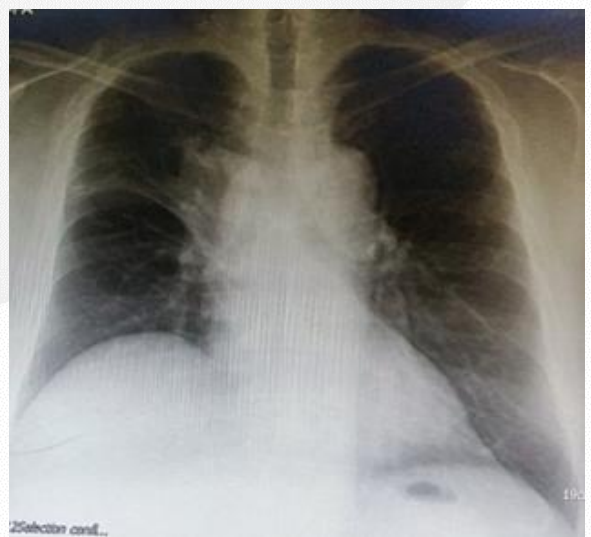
Postero-anterior chest radiograph after month 1 of chemotherapy
